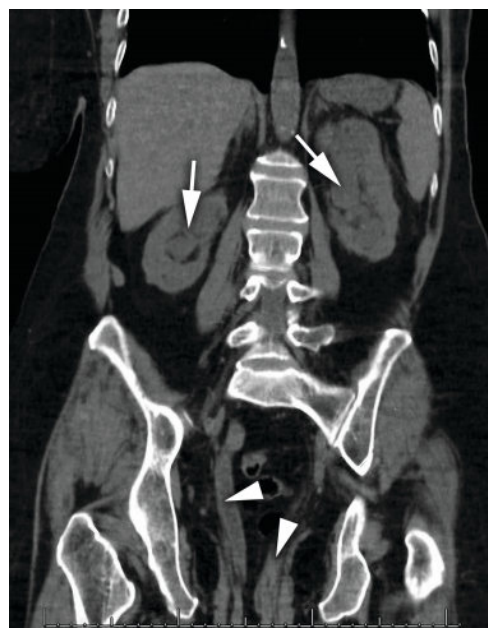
Abdominal computed tomography: coronal view of bilateral hydronephrosis (arrows) and hydroureter (arrow-heads); pelvic cavity with nonvisible uterus and bladder.
